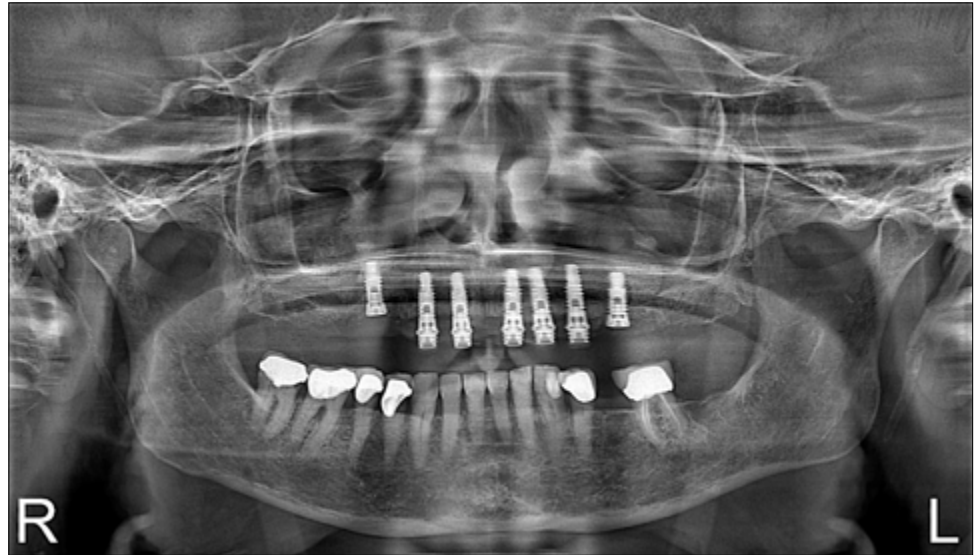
Panoramic radiograph showing all healing of the new two implants.
